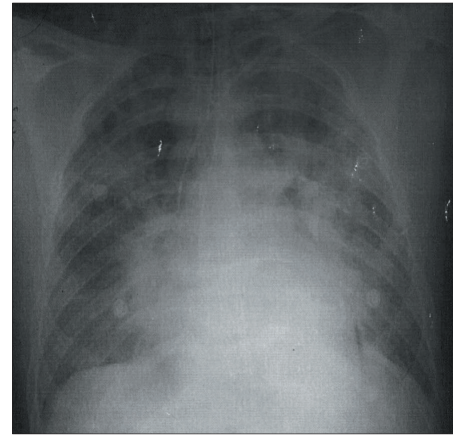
Chest x-ray of the patient showing acute pulmonary edema.
